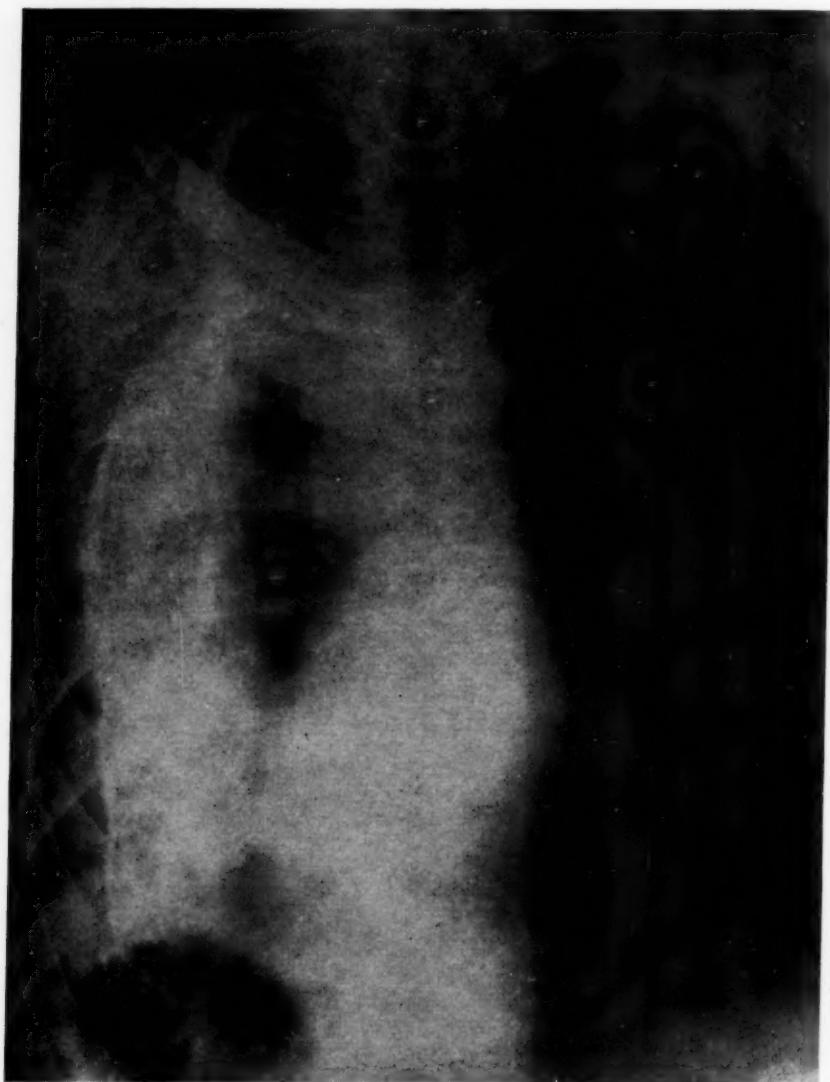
Roentgenogram showing calcification of the pleura in a man 48 years old. Pleurisy with effusion occurred at the age of 20 years.
